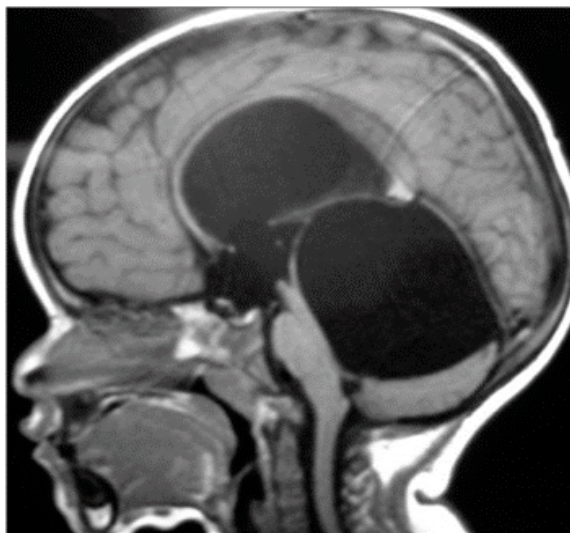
Sagittal T1 MRI at diagnostic evaluation: large quadrigeminal cyst causing hydrocephalus and compressing the brainstem and the fourth ventricle.
